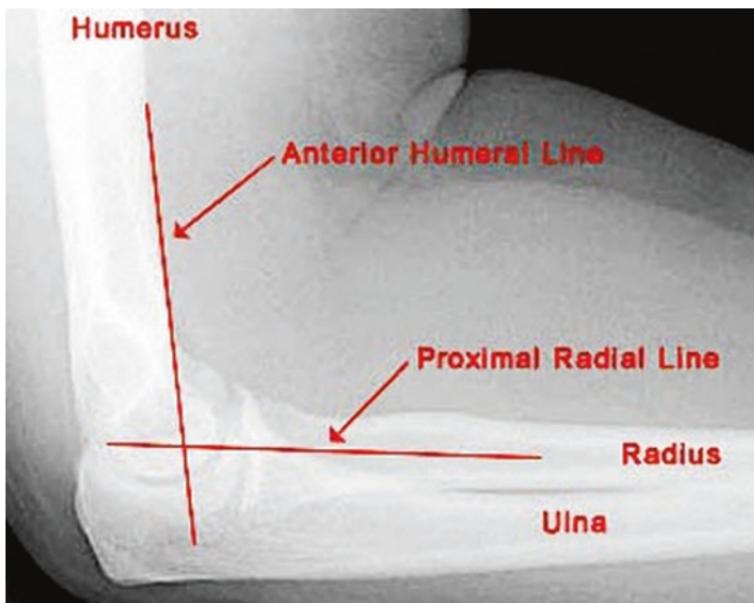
Normal elbow radiograph: Anterior humeral line should intersect the middle third of the capitulum, and the radial line should engage its center. (Reprinted from: <http://skeletaltrauma.wikispaces.com/Elbow>. With permission from Creative Commons Attribution: <https://creativecommons.org/licenses/by-sa/3.0/>)
